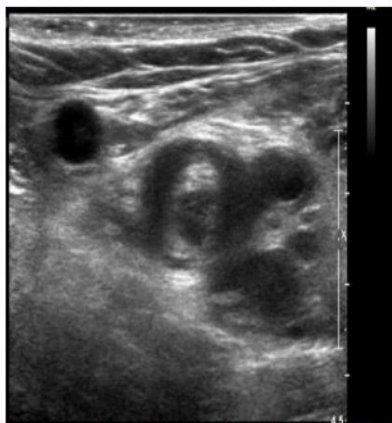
Ultrasound of the right lower limb in a 66 year old woman, who was diagnosed with COVID-19. The image shows soft intraluminal material and a non-compressible venous segment of the femoral vein as signs of acute deep vein thrombosis.
